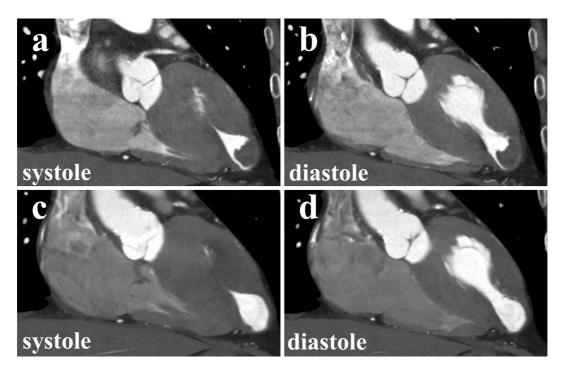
Enhanced computed tomography revealed an apex aneurysm and thrombosis (a and b). After anticoagulation therapy with warfarin, the apex thrombosis disappeared (c and d).
